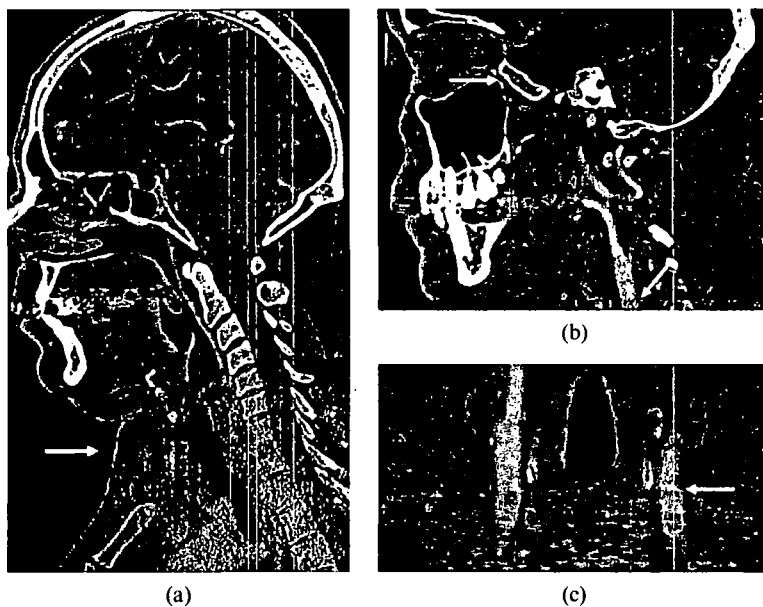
Frequently encountered artefacts in 320-slice cervicocranial 3D CTA. (a) Decreased image quality of the lowest shot at the shoulder girdle level (arrow). (b) Shift of structures at the end of scans due to geometric distortion (arrows). (c) In arterial structures, this can be clearly pronounced, probably as a result of pulsation (arrow).
